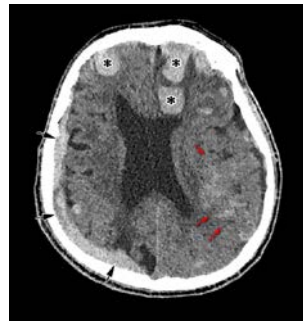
Multifocal hemorrhages, the largest being located bilaterally in the frontal lobes (asterisks). A right subdural hematoma (black arrows) was also present, and a left frontoparietal subarachnoid hemorrhage (red arrows) in an axial computed tomography scan.
